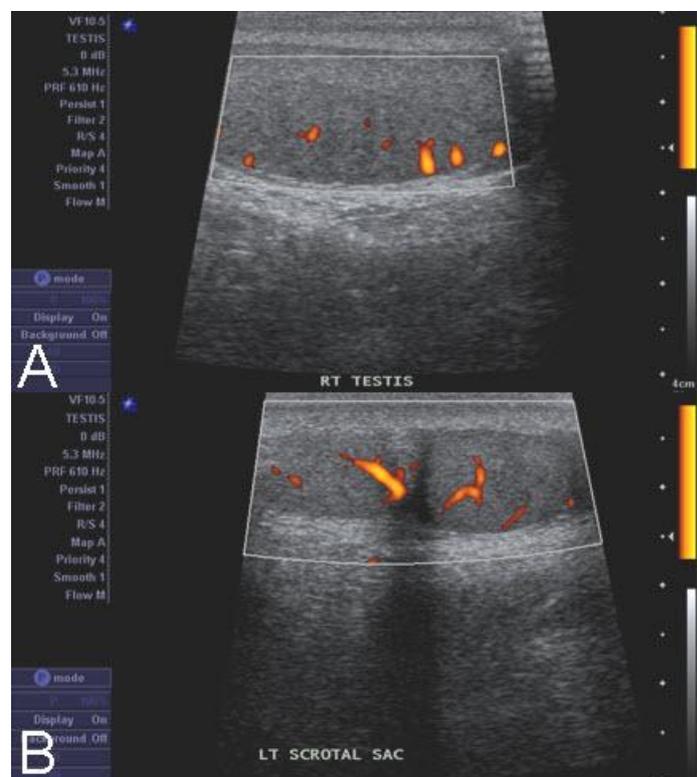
13 year old patient with polyorchidism. (a) Power doppler (linear probe, 5.3 MHz) image of right testis. (b) Power doppler (linear probe, 5.3 MHz) of left hemiscrotum showing colour flow in both the testicles.
